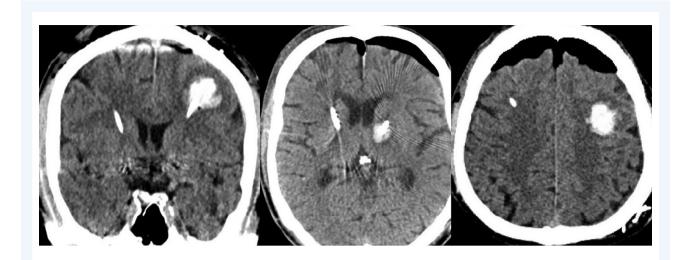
Postoperative computed tomography scan showing postoperative hemorrhage after DBS (deep brain stimulation) surgery.
